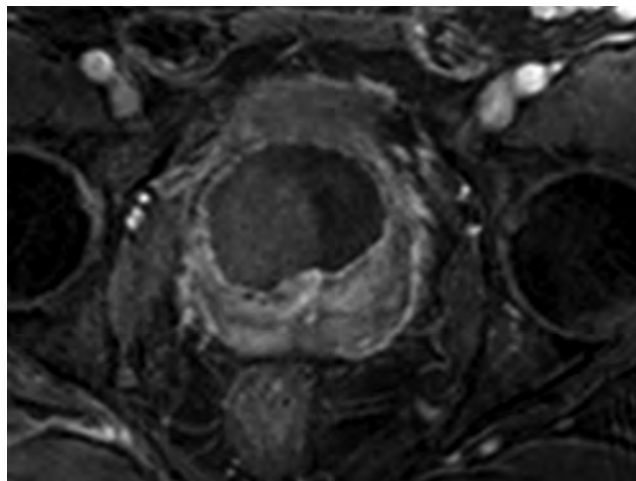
Early 2-week contrast-enhanced magnetic resonance imaging after focal cryotherapy in the man from [Figure 117-24](#) showed confluent lack of perfusion in the area of ablation. He had no urinary leakage, and erections were sufficient for penetrative sexual intercourse.
